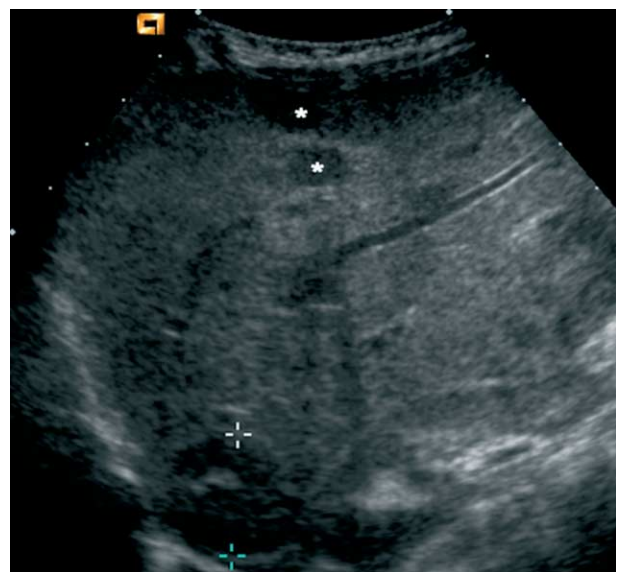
Ultrasound longitudinal section through the right lobe of the liver demonstrating a low reflectivity lesion between callipers and two further lesions indicated by asterisks.
